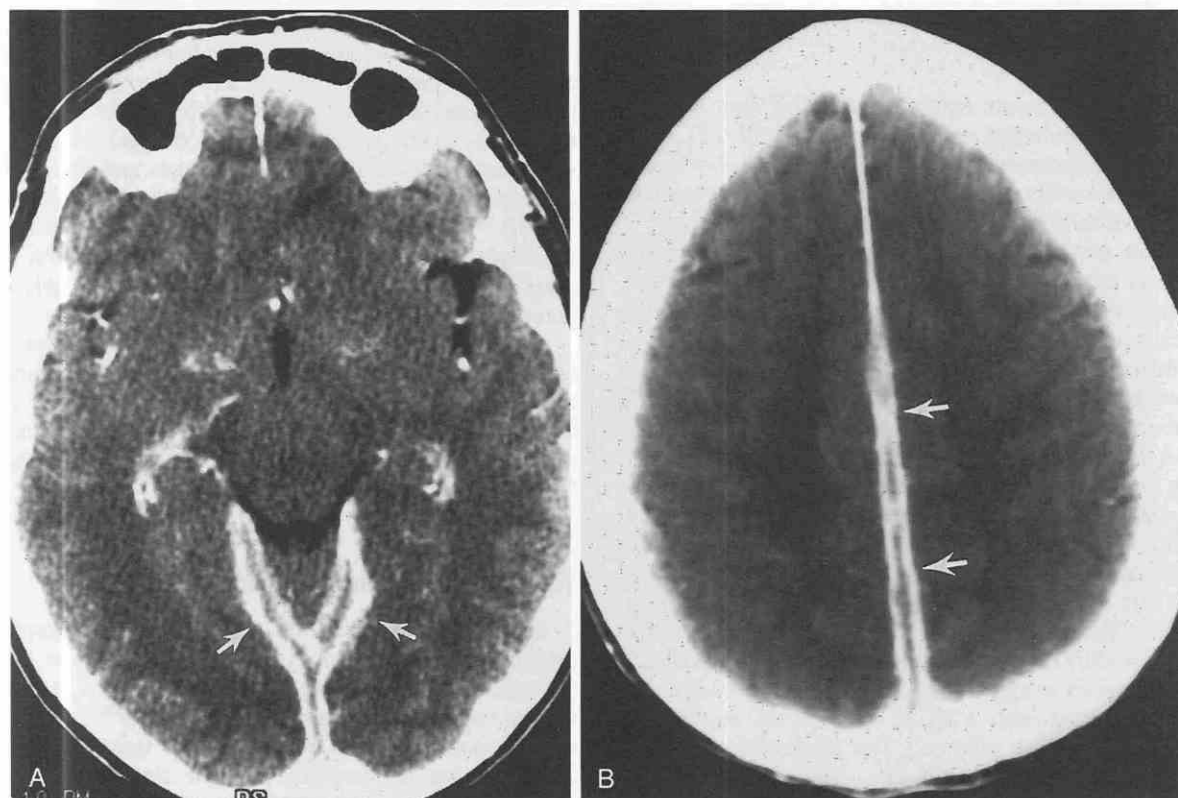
Wegener's granulomatosis. *A* and *B*, Diffuse thickening and enhancement of the meninges in a dura/arachnoid pattern (*arrows*) are present in a patient with biopsy-proven Wegener granulomatosis on a contrast-enhanced CT scan.
